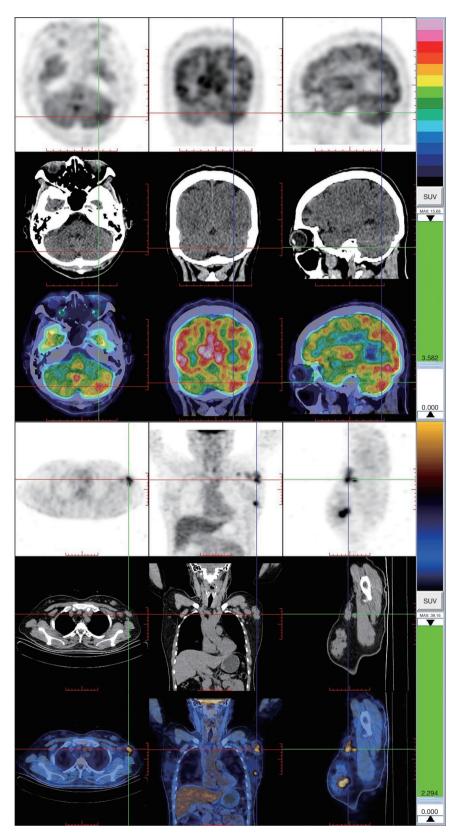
Positron emission tomography-computed tomography image. SUV, standardized uptake value.
